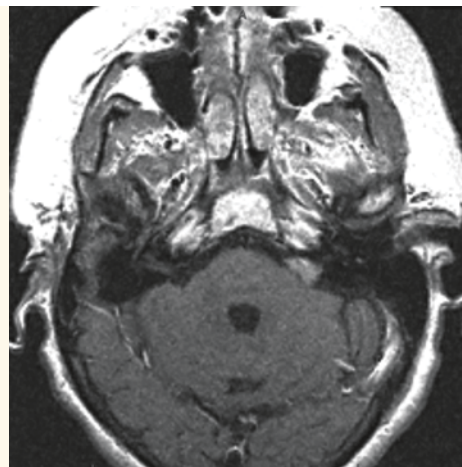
(Right) Follow-up MRI 10 years after GKS demonstrating tumor regression.
